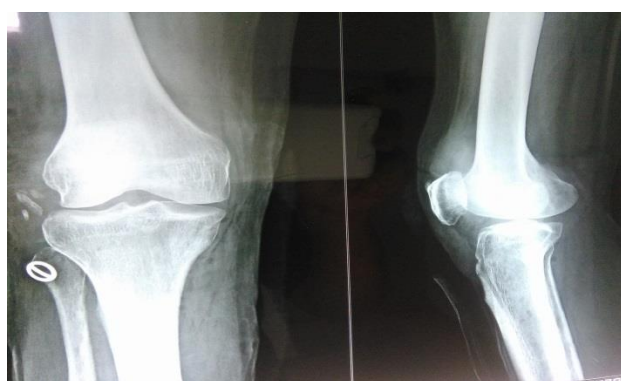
Postoperative X-ray titanium button is well seated at fibula head.
